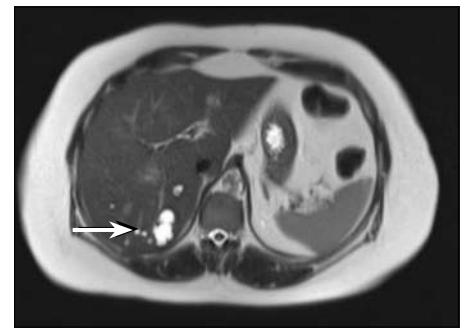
Transaxial T2-weighted image from a magnetic resonance study of the abdomen performed on October 27, 2009, demonstrates a fluid-signal lesion in the right posterior hepatic lobe with some internal septations, consistent with a complex cyst (arrow). This corresponds to the region of abnormal I-131 tracer accumulation as well as the low-density hepatic lesion on the abdominal CT scan.
